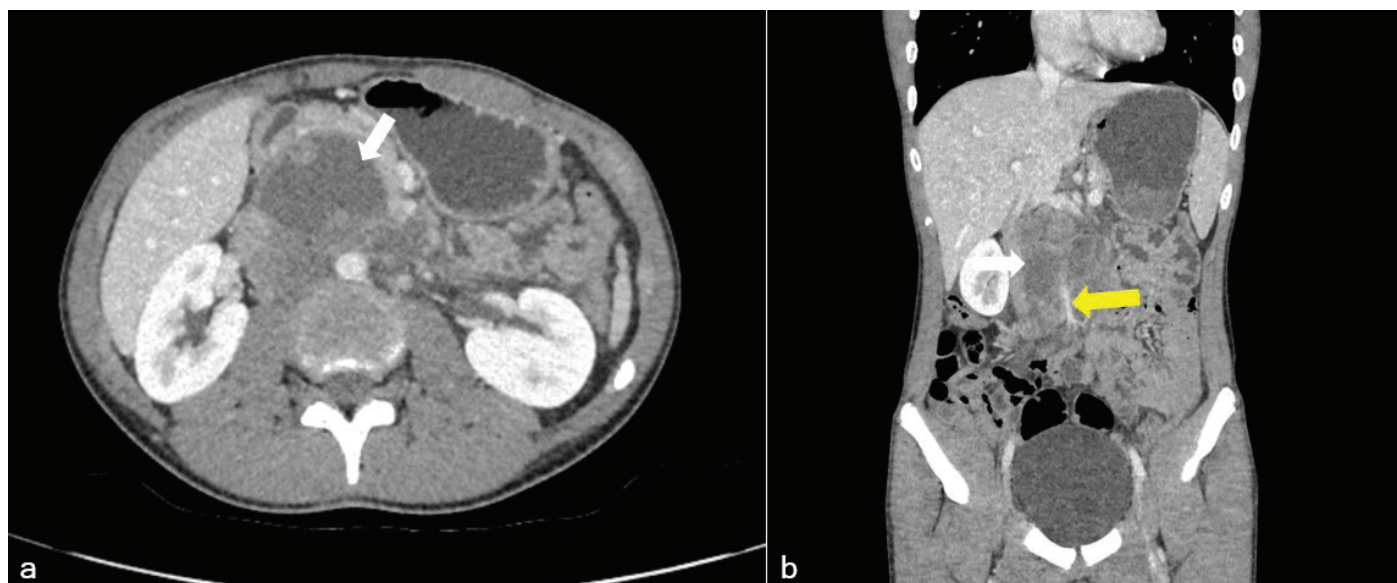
Contrast-enhanced axial section (a) abdominal CT image reveals largely necrotic conglomerated lymphadenopathies (indicated by a white arrow) with obliteration of the aorta and the intermediate fat plane. The contrast-enhanced coronal section (b) abdominal CT image demonstrates the craniocaudal extension of the necrotic conglomerated lymphadenopathies (white arrow) and their close proximity to the superior mesenteric artery (yellow arrow).
